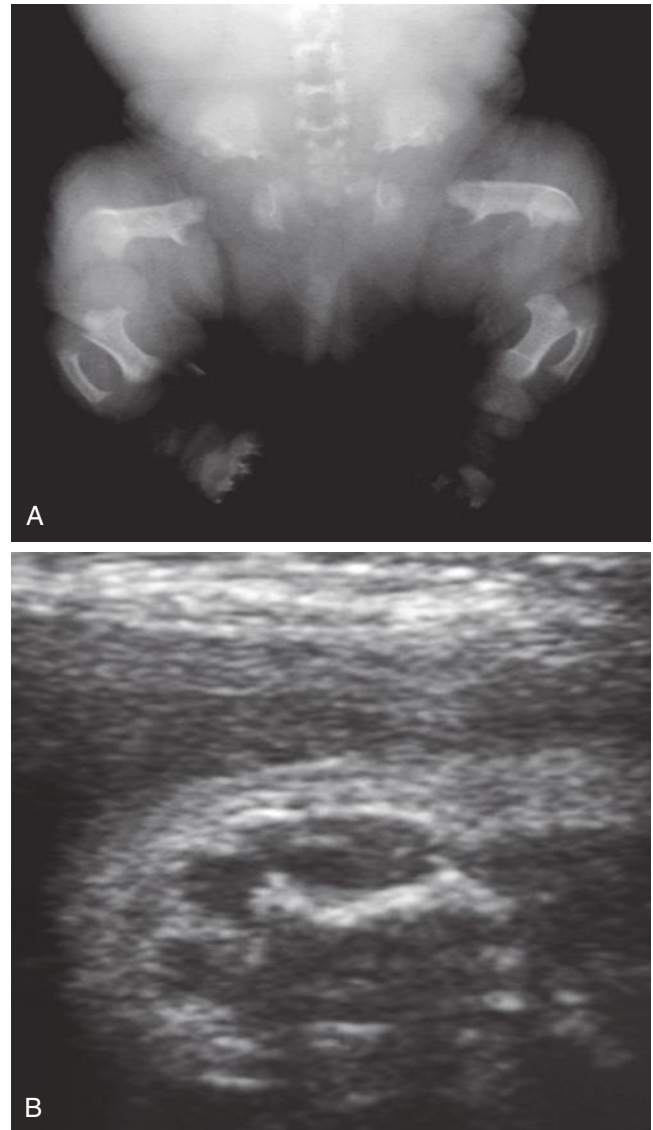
A, Radiograph of a patient with thanatophoric dysplasia. Marked limb shortening and characteristic bowed “telephone receiver” femora. B, Sonogram of a fetus with thanatophoric dysplasia with marked femoral shortening and bowing.
